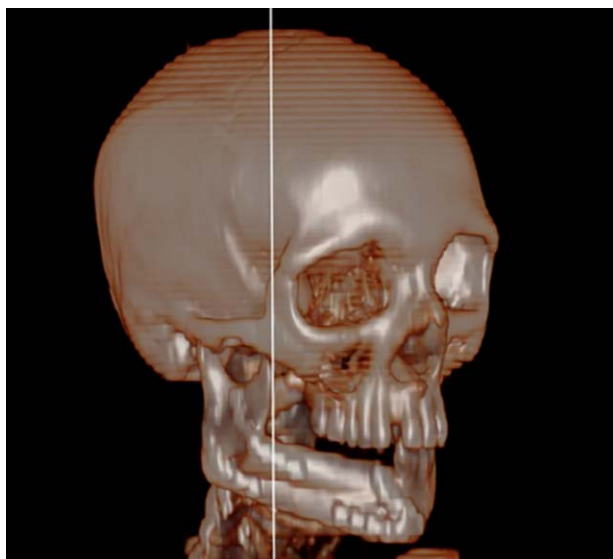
Computed tomography 3D rendering after 3 months from surgery is possible to see the perfect integration of the osseous flap.
